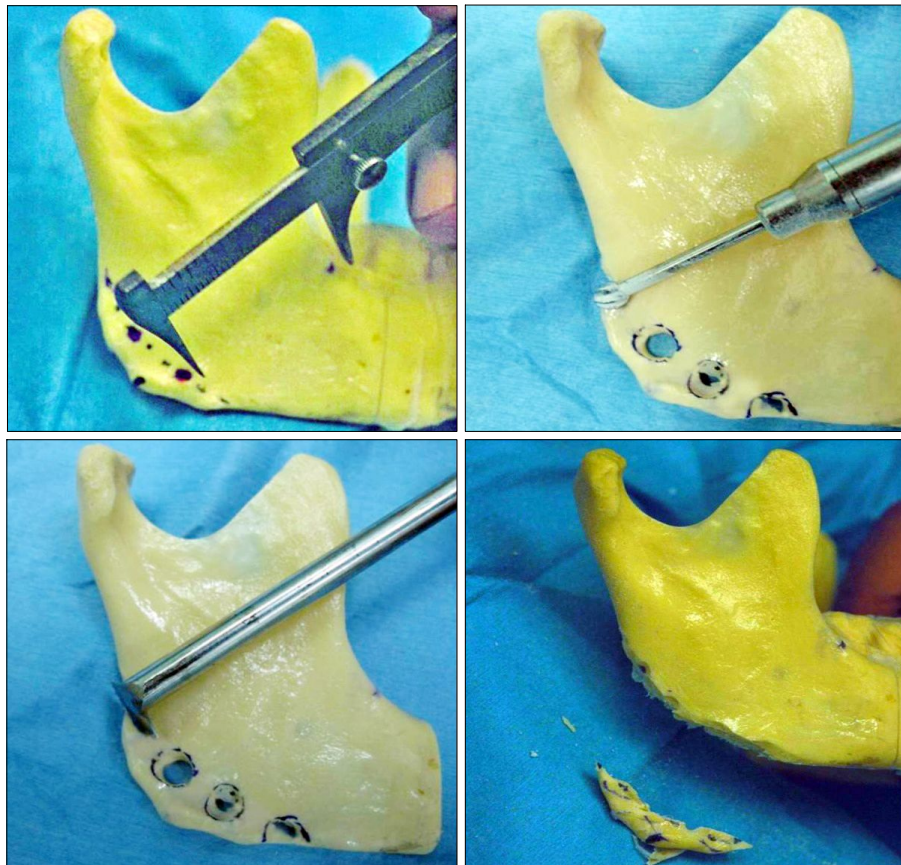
(Above, left) Distances from reference point to burring points are checked and are compared to calculated distance from X-ray. (Above, right) Multiple holes are made with large headed burrs. (Below, left) Osteotomy is performed with oscillating saw. (Below, right) Bone fragment is removed and irregularities are corrected by light burring.
